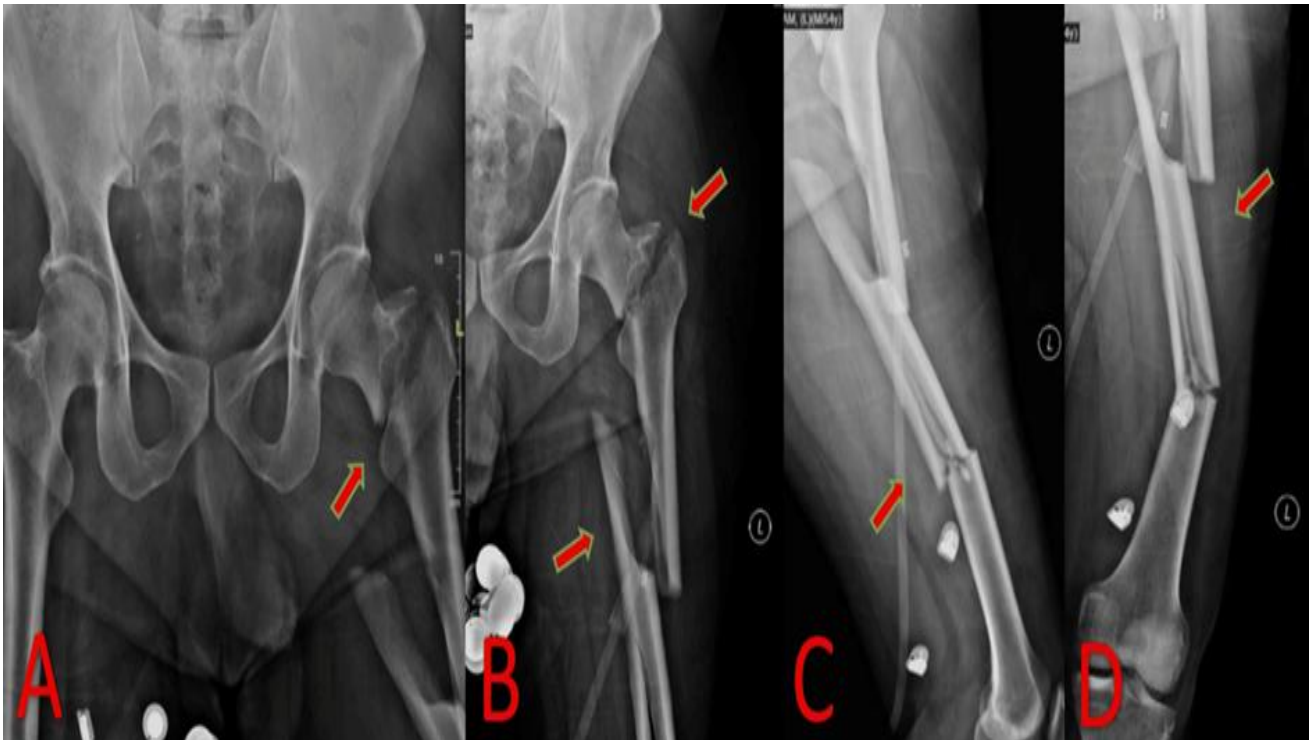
(A-D): Pre-operative radiographs of the left femur in case 2 showing an intertrochanteric femur fracture (AO-31A1.2) along with a segmental shaft of femur fracture (AO-32C2). (A) Anteroposterior view of pelvis with bilateral hip showing intertrochanteric fracture of left femur. (B) Anteroposterior view of left femur showing intertrochanteric fracture of left femur and proximal shaft of femur fracture. (C) Lateral view of left femur showing intertrochanteric fracture of left femur and segmental shaft of femur fracture. (D) Anteroposterior view of left femur showing segmental shaft of femur fracture.
